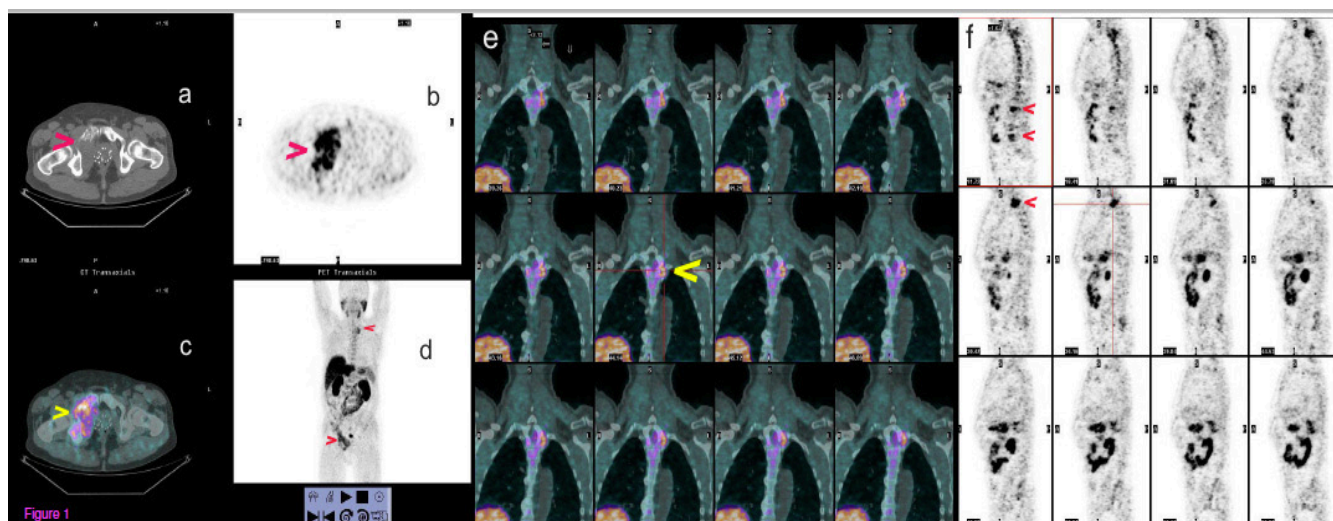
PET-CT scan obtained 1 hour after FCH injection. a: CT transverse section showing extensive lytic involvement of the right hemipelvis (arrowhead). b: corresponding PET slice, showing an intense FCH accumulation in the bone and surrounding soft tissue of the pelvic floor. c: PET-CT fused image, note the absence of FCH accumulation in the right prostatic bed (125I seeds implanted). d: MIP (maximum intensity projection) showing FCH accumulation in the right hemipelvis and thoracic spine. Physiological uptake in the salivary glands, liver and gut. e: fused coronal PET-CT views of the thoracic spine, vertebral and perivertebral FCH accumulation (arrowhead). f: sagittal PET views of the spine showing accumulation in the thoracic and lumbar spine (arrowheads).
